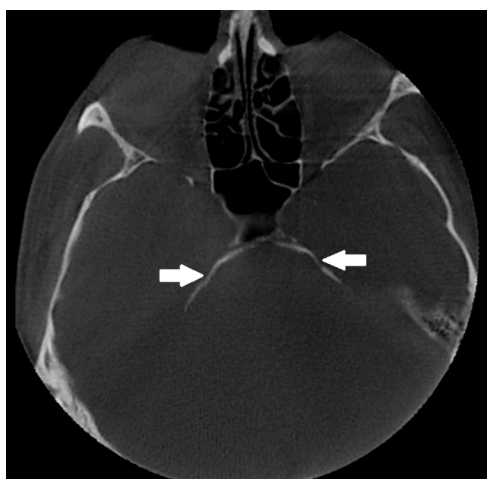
Axial CBCT image of bilateral petroclinoid calcifications (arrows).
